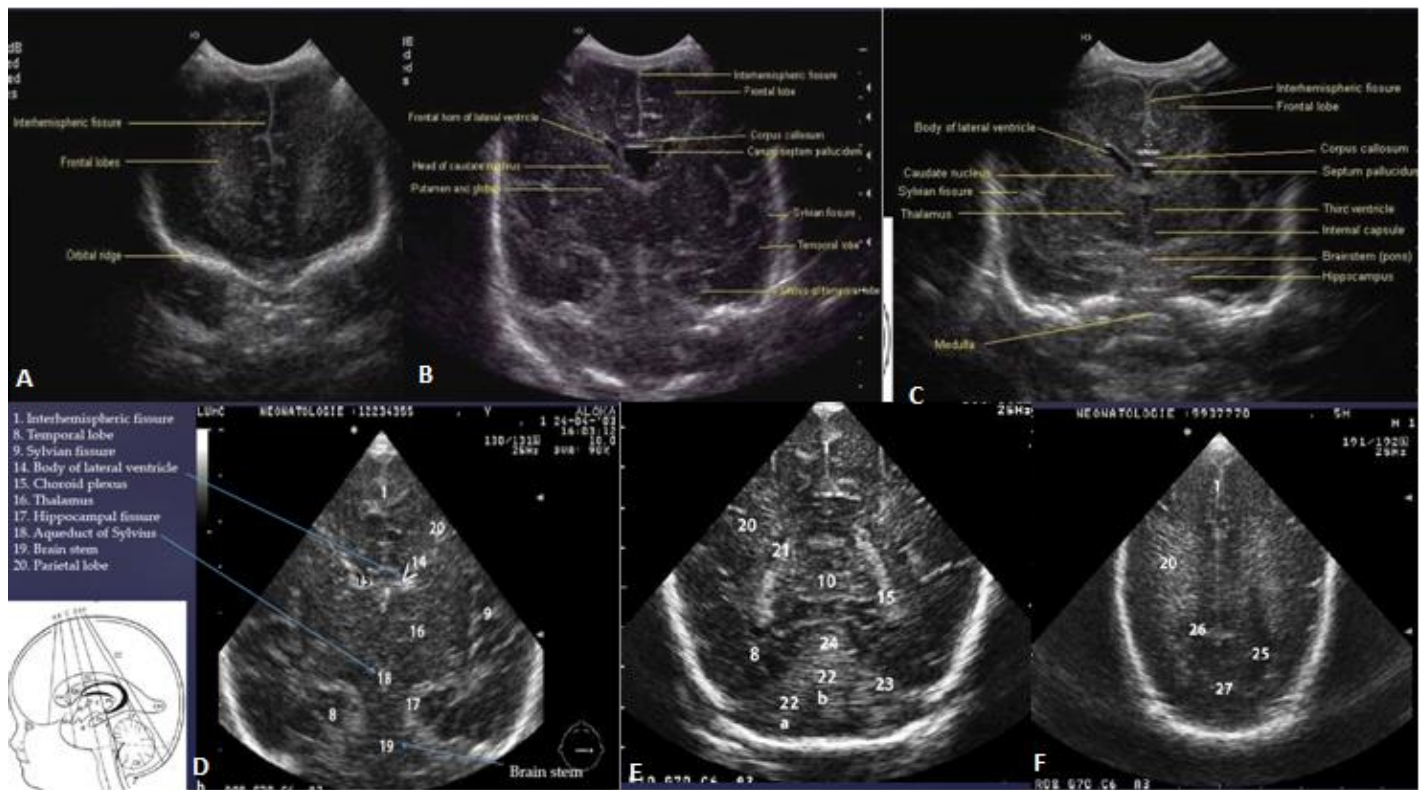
Ultrasound Images Showing the Six Standard Coronal Planes for TCUS
